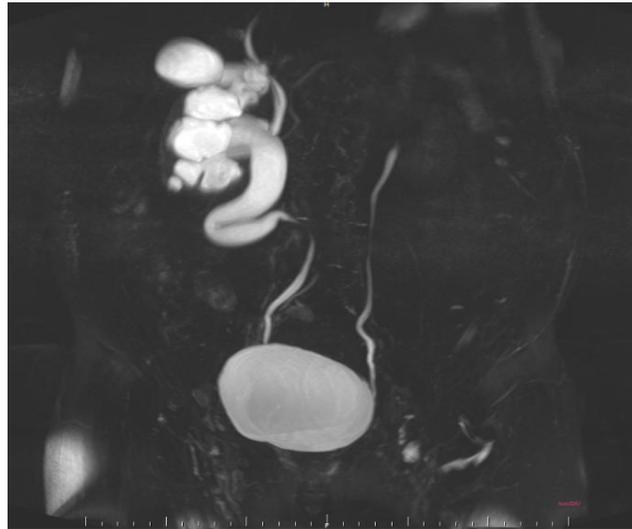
Right PUJ obstruction. MRI COR. T2WI. Right sided moderate to gross hydronephrosis
